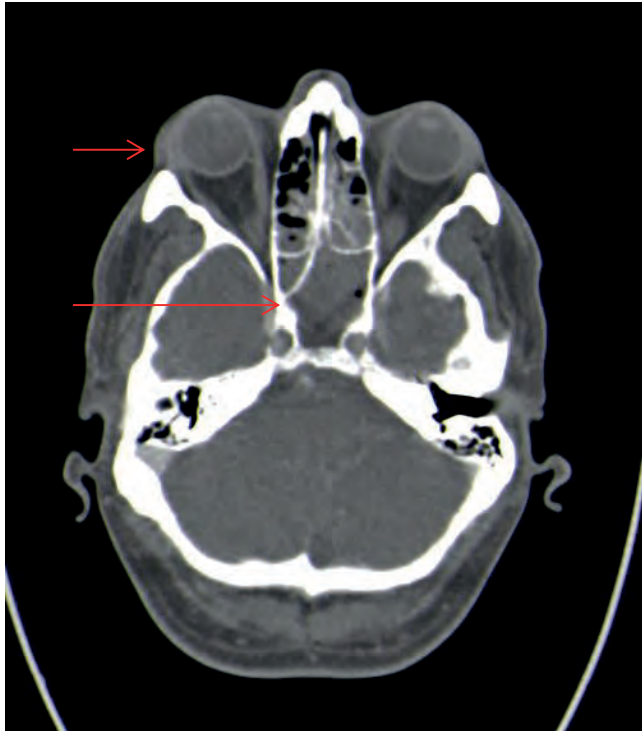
CT Venogram showing exophthalmos on the right (short arrow) and sphenoid sinusitis (long arrow)
